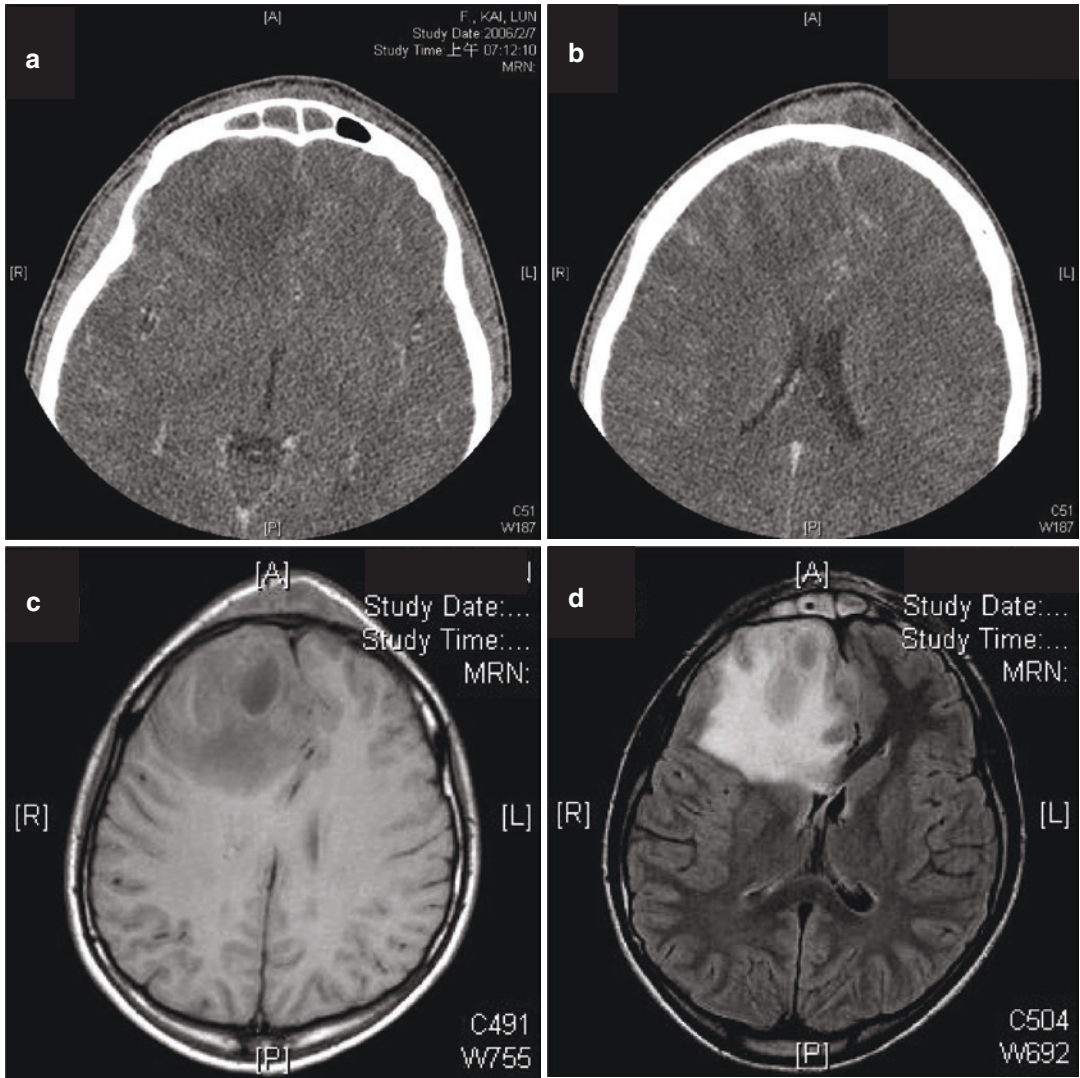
(a, b) CT scan of head revealed frontal sinusitis with subperiosteal abscess formation. (c, d) MRI of brain showed a brain abscess at right frontal region with perifocal brain edema
